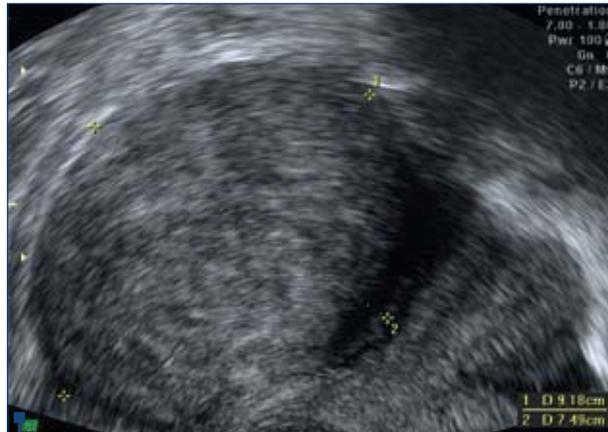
Ultrasonographic findings of a uterus with a huge (92 mm/75 mm) atypical leiomyoma (in case 2). (left side - myoma, right side - uterus)
